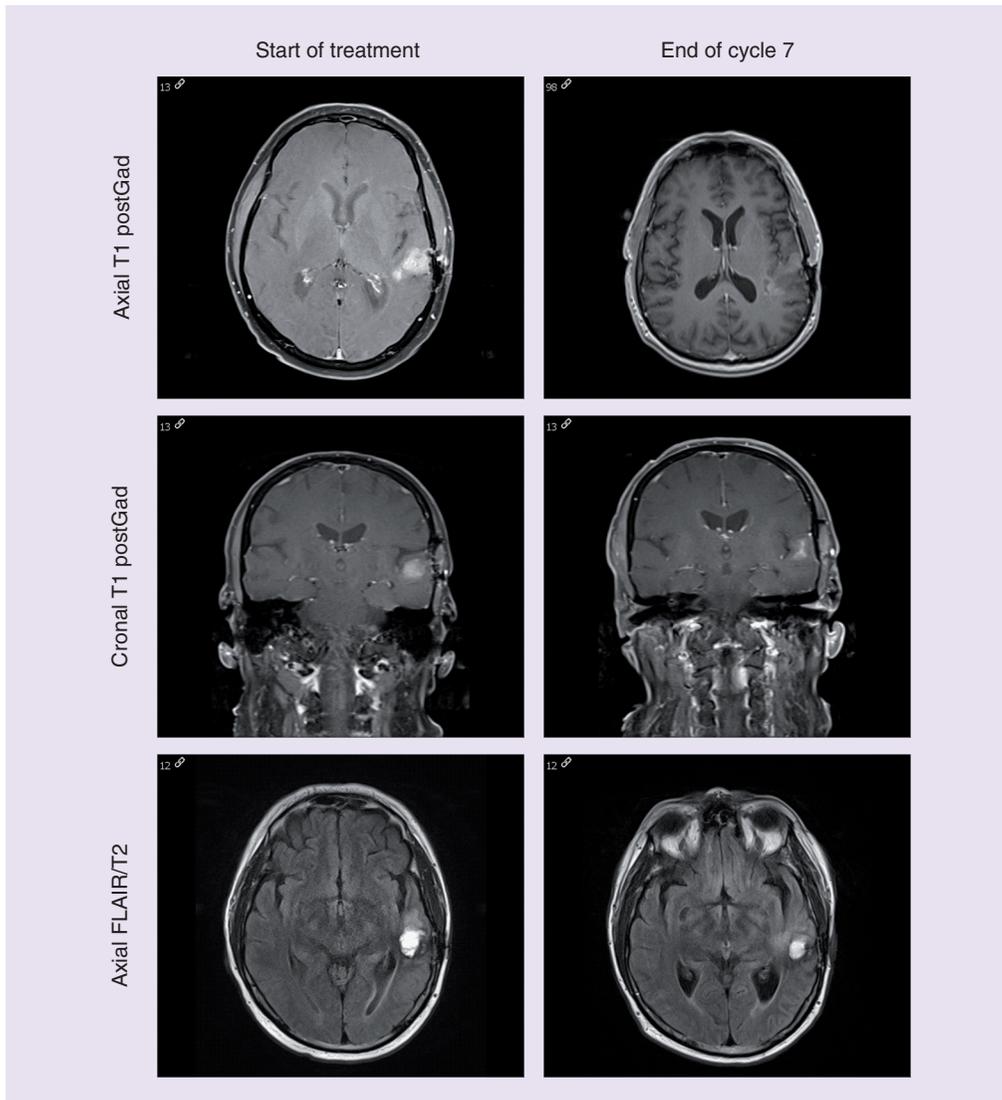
MRI of the brain for a patient randomized to the ERC1671/bevacizumab arm. Showing the tumor size before starting in the ERC1671/bevacizumab treatment and end of cycle 7. The MRI shows significant decrease in contrast enhancement over time and stable fluid-attenuated inversion recovery signal.
